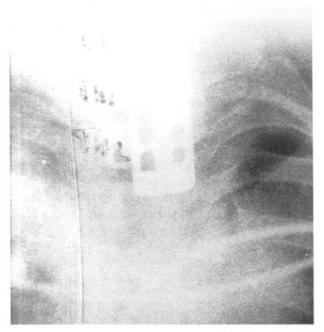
Postoperative plain radiograph of the patient.
